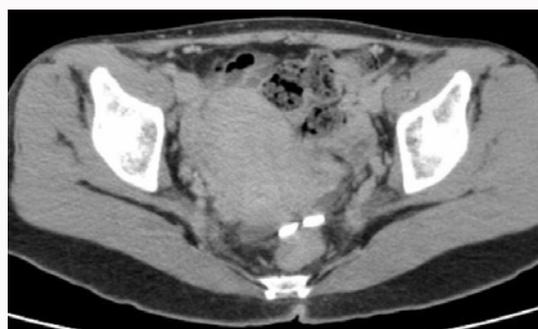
A leftward displaced IUD was found upon computed tomography.
